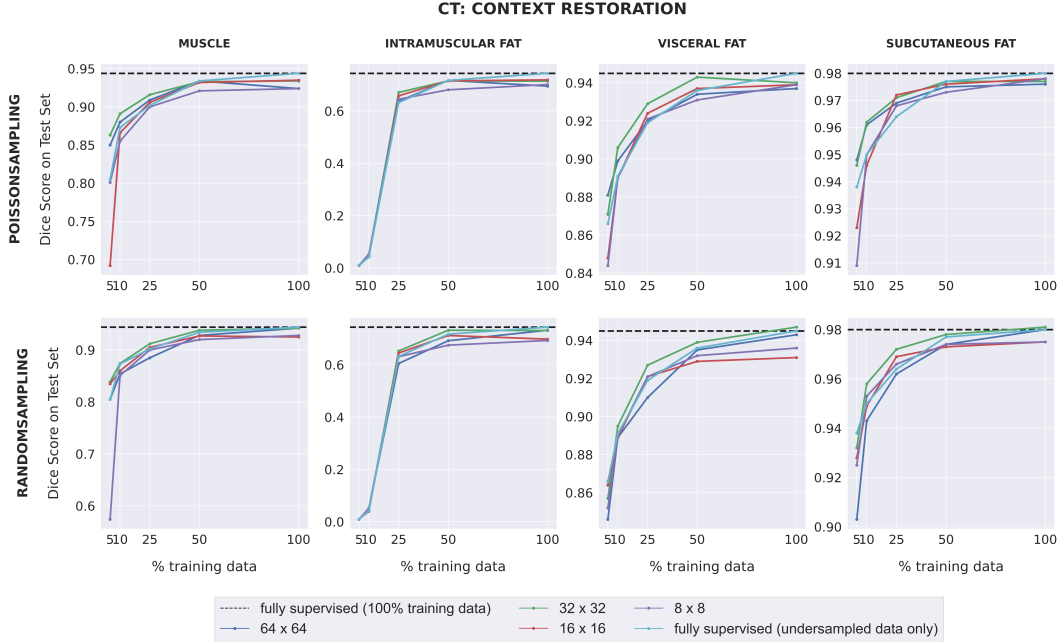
The downstream segmentation performance on the CT dataset for the Context Restoration pretext task as measured by the Dice score for every combination of patch size and sampling method used during pretraining, evaluated in five different scenarios of training data availability. In each scenario, every model is trained for segmentation using one of the five different subsets of training data as described in Section 2.1.2. The black dotted line in each plot indicates the performance of a fully supervised model trained using all available training images. The light blue curve indicates the performance of a fully supervised model when trained using each of the five different subsets of training data. Similar plots for the Context Prediction pretext task are given in the Supplementary Section.
